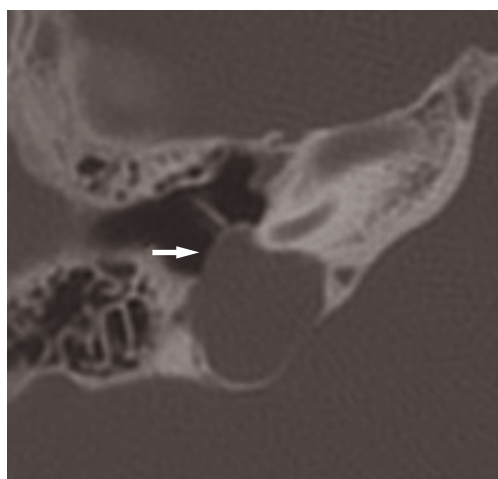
Axial CT scan. Tympanic dehiscence of the jugular bulb (arrow).
